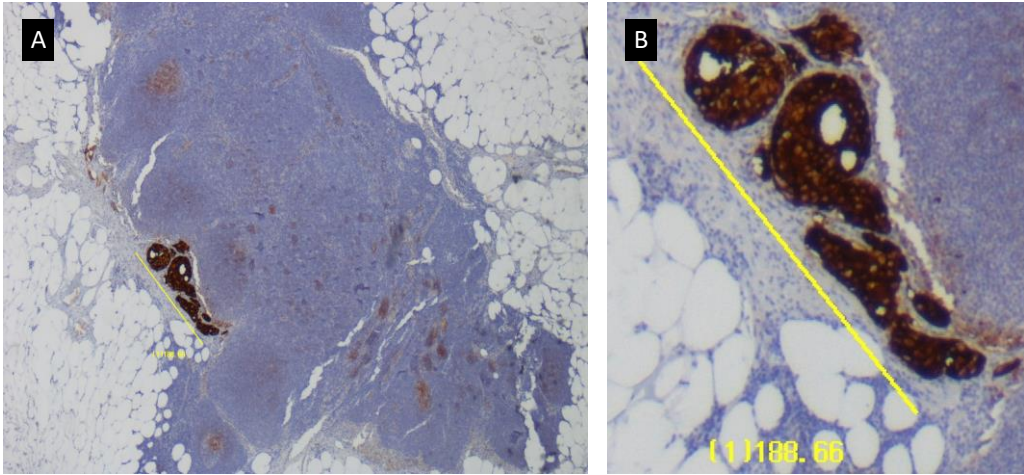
Example of a patients with lymph nodal micro-metastatic disease. Sub-millimetric cancer metastasis within the entire lymph node parenchyma (Figure A) was not identified despite having a homogeneous PSMA 3+ expression (Figure 3), showing the dimensional limitation of the PSMA RGS.
